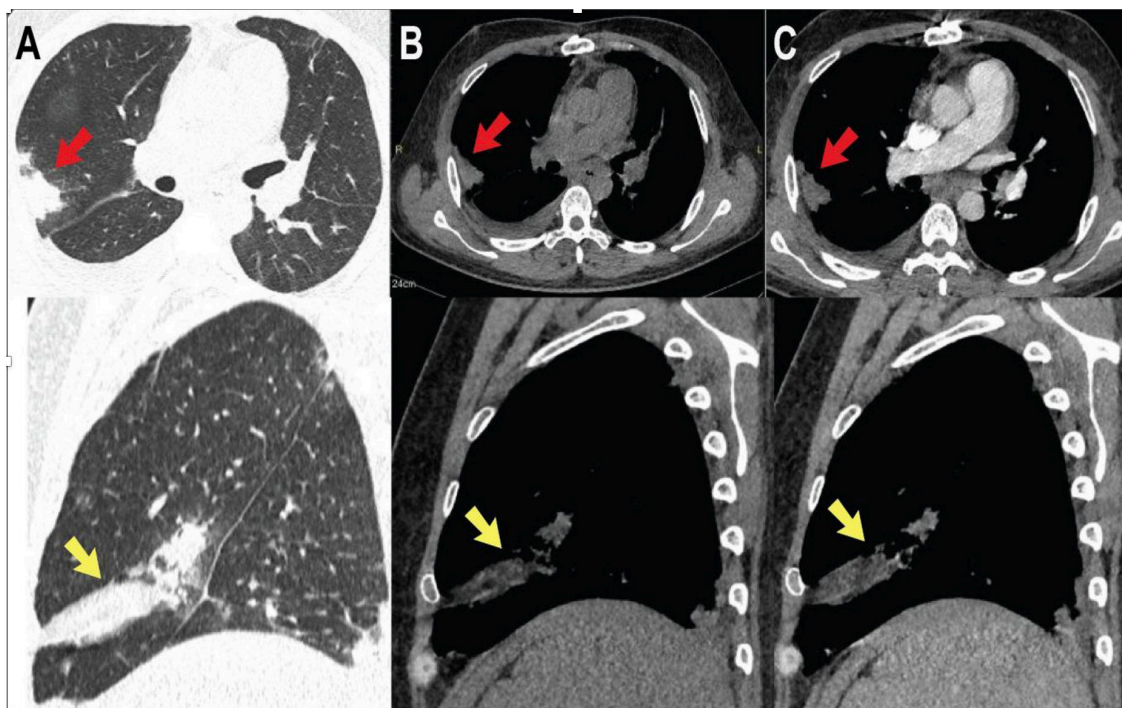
Thoracic CT images in the lung (A) and mediastinal (B, C) windows, displayed in axial (upper panels) and sagittal (lower panels) views, demonstrating subpleural wedge-shaped opacities in the right lung (red arrows) and left lung (yellow arrows).
